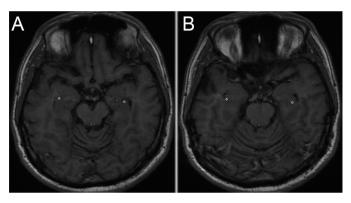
Position of the DBS electrode contacts in bilateral hippocampal heads. The images after fusion of postoperative CT and preoperative MRI revealed that the bilateral white round rings were intracranial DBS electrodes in bilateral hippocampal heads. The third and fourth contacts were located in hippocampal head on each side, while the first and second contacts were located in parahippocampal gyrus. (A) the fourth pair of DBS electrode contacts and (B) the third pair of DBS electrode contacts.
